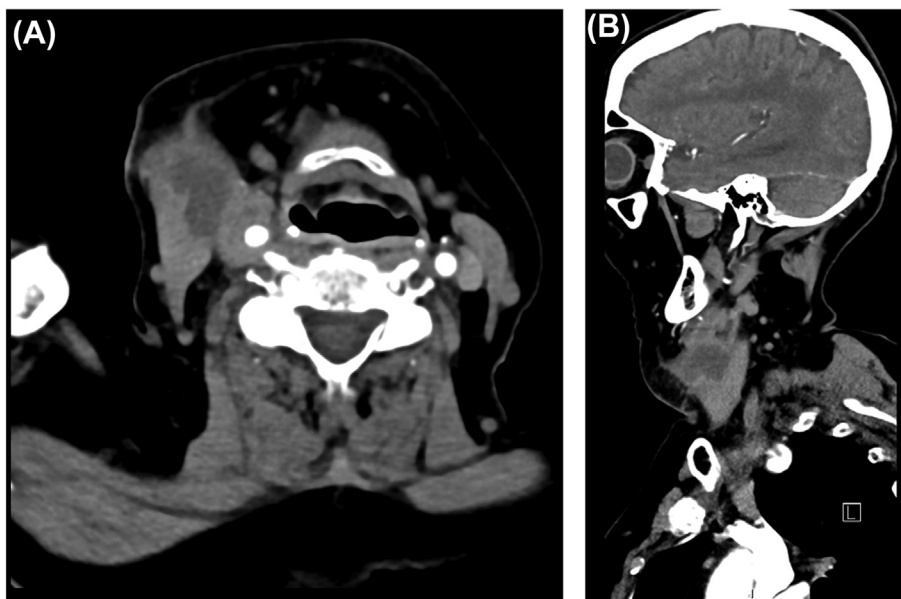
Collection relating to the right internal carotid artery demonstrated in axial (A) and sagittal (B) CT images.
